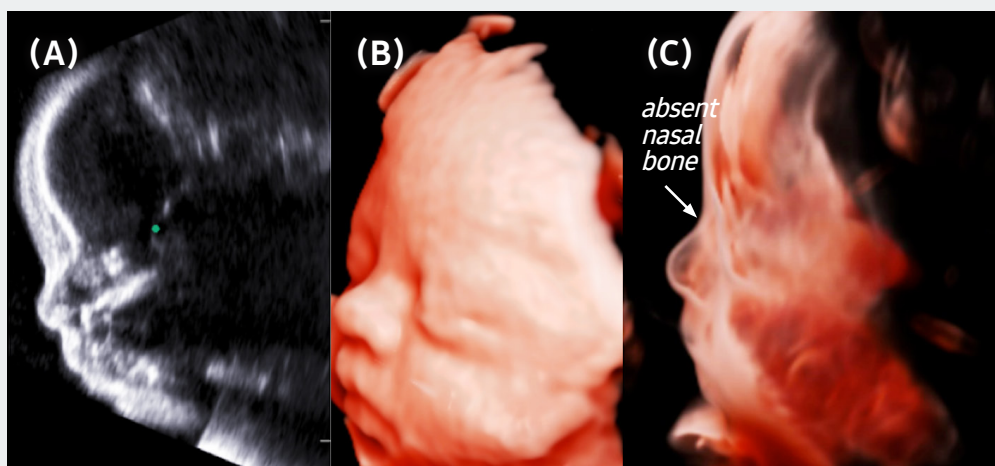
Fetus in the third trimester with trisomy 21: image of the fetal face in 2D ultrasound (A), RealisticVue™ rendering (B), CrystalVue™ rendering (C). Note that image (C) is the only case where absence of the fetal nasal bone is clearly visible.
